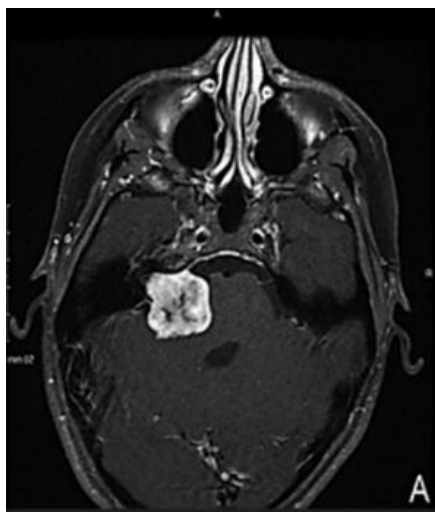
14 days pre-procedure T1-weighted MR imaging.
